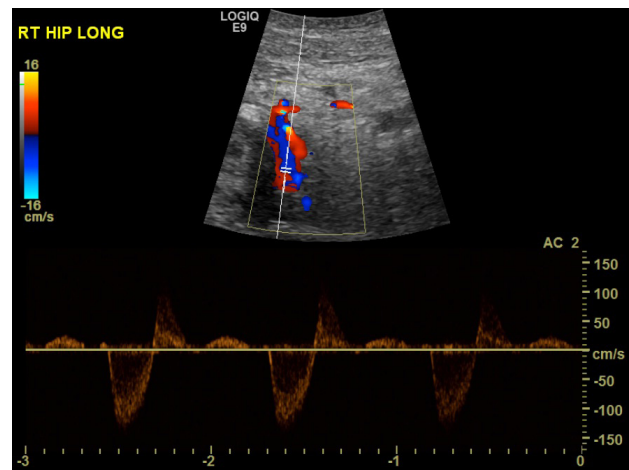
Doppler ultrasound appearance 'to and fro' waveform suggestive of pseudoaneurysm.
